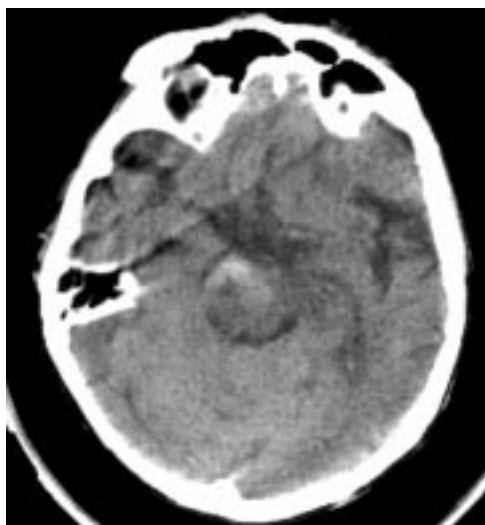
Computed tomography without contrast showing blood in and around the pons and deep white matter of the right cerebral hemisphere.
